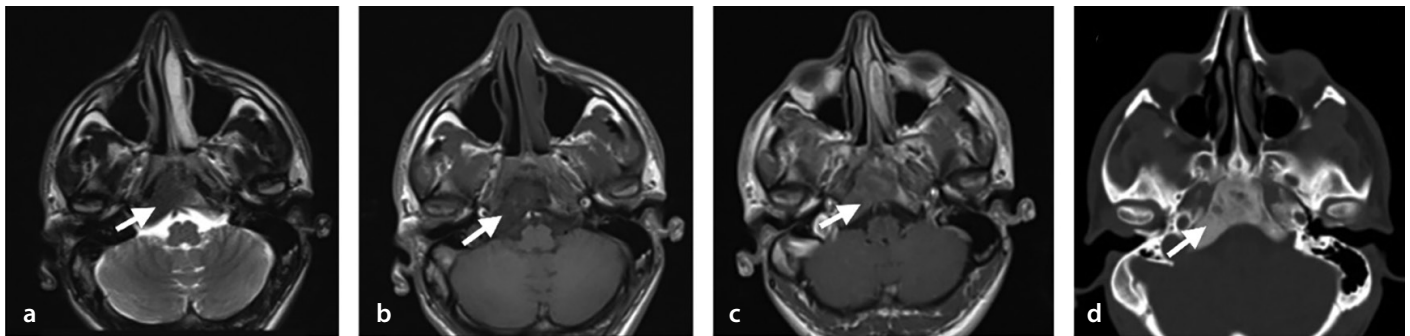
Imaging features of a lesion consistent with monostotic fibrous dysplasia in the clivus in a 31-year-old male patient. An incidental lesion in the clivus, appearing hypointense on T2-weighted (a) and T1-weighted (T1W) (b) sequences. The lesion is intramedullary in location and mildly expansile (arrow). On post-contrast T1W imaging (c), the lesion exhibits moderate enhancement, raising suspicion for fibrous dysplasia, and a computed tomography (CT) scan was recommended. The CT scan (d) confirms a well-defined, mildly expansile lesion with ground-glass density, supporting the diagnosis of fibrous dysplasia (arrow).
